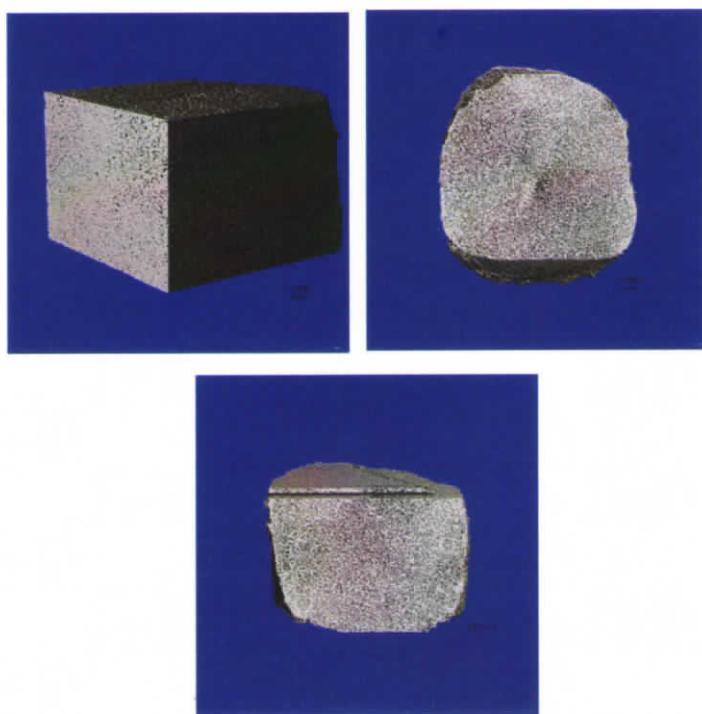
Micro CT images of Gelatin-Albumin scaffolds taken at different cross sections
